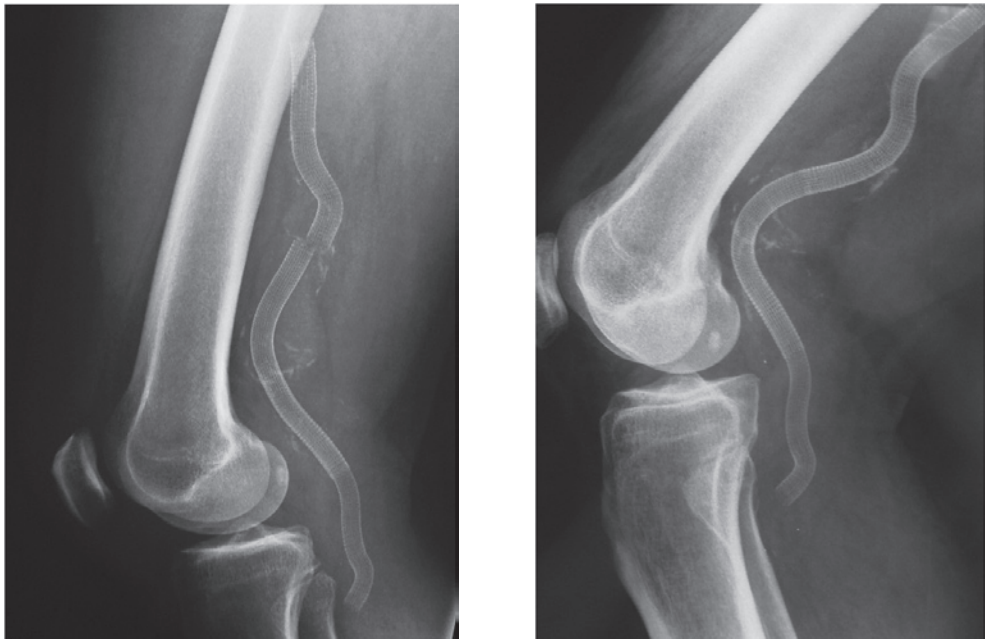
Radiograph of the knee in lateral projection shows disconnection between two overlapping stent-grafts before (left) and after (right) correction with a bridging stent-graft.
